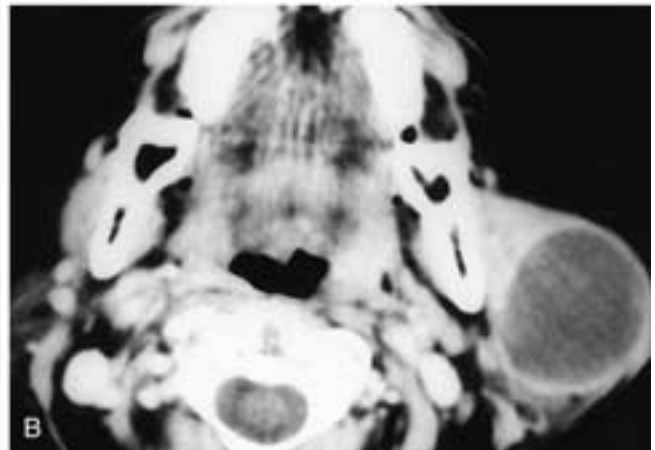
Axial CT scan (A) shows a smooth-walled cyst in the superficial portion of the right parotid gland. This patient had a type 1 first branchial cyst. Axial contrast-enhanced CT scan (B) on another patient shows a smooth-walled left parotid cyst. At surgery this was found to be a type 2 branchial cyst.
